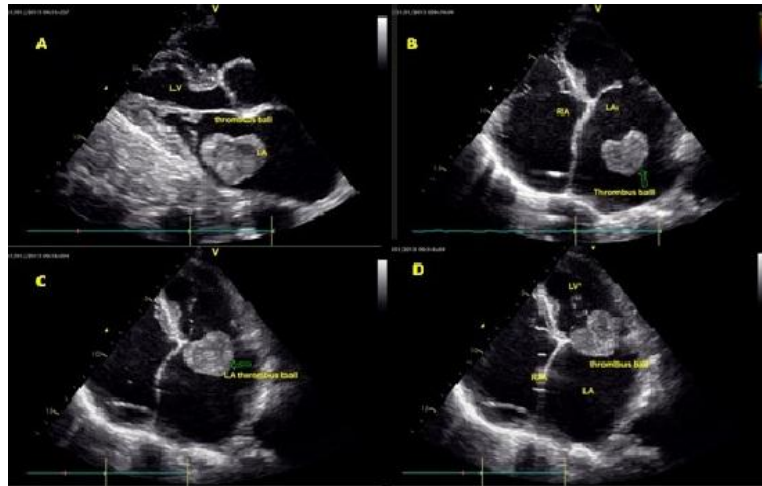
(A, B): Long axis parasternal (A) and 4-chamber apical view (B) showing “heart shaped” left atrial free floating thrombus-ball.
